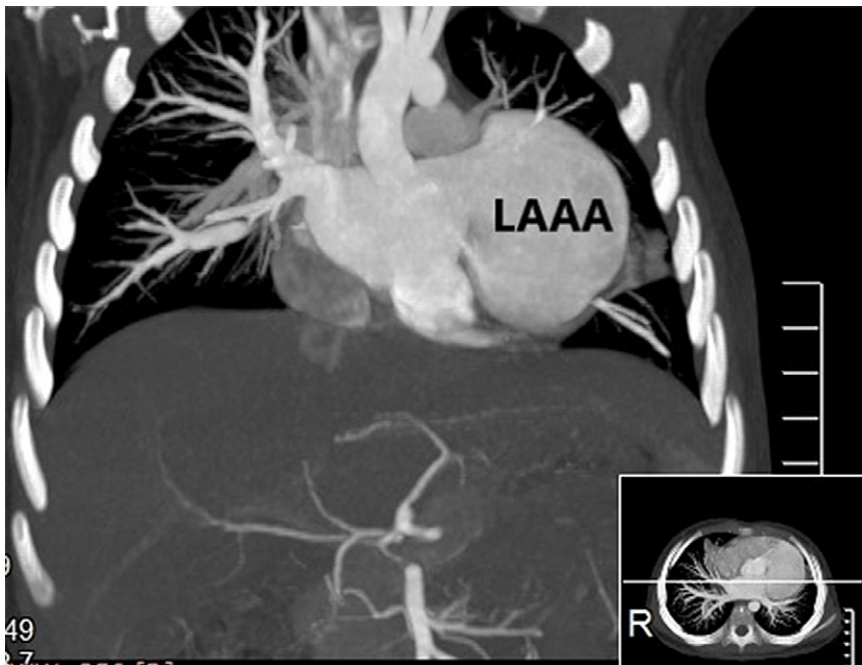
Preoperative CT scan showing the left atrial appendage aneurysm (LAAA, left atrial appendage aneurysm).
